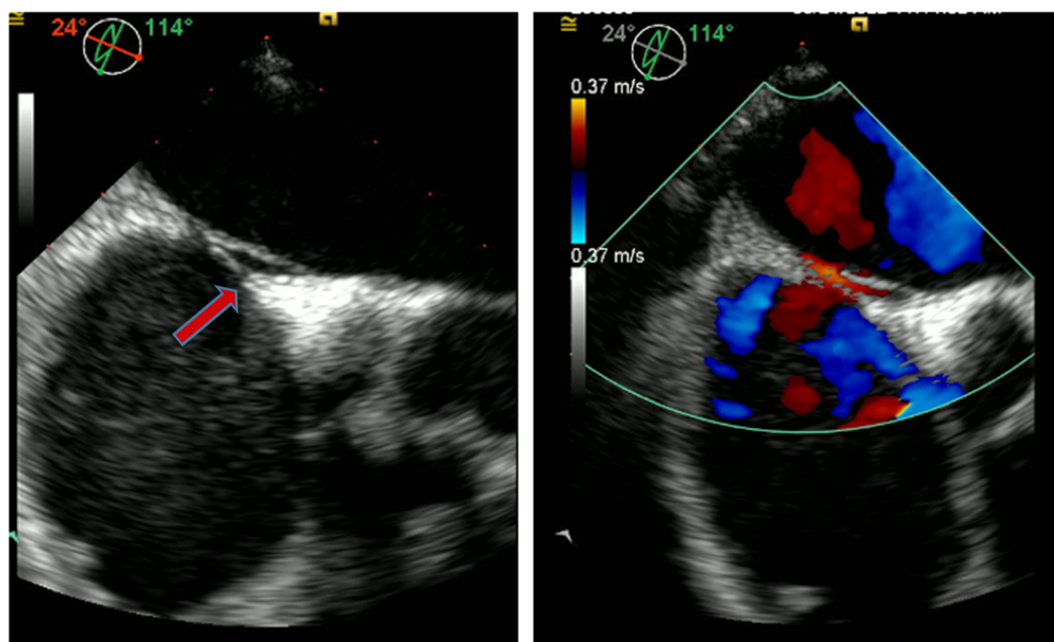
A 2D transesophageal echo image (114°) of a patent foramen ovale (PFO; red arrow) with shunting evident on the color flow Doppler.
